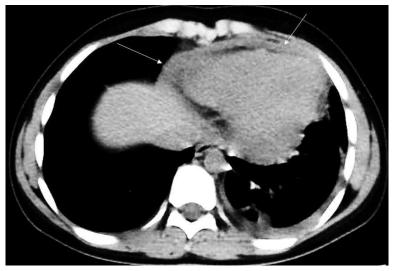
Lupus pericarditis. Axial chest CT image of a patient with SLE showing a moderate pericardial collection and pleural effusion of the left lung.
